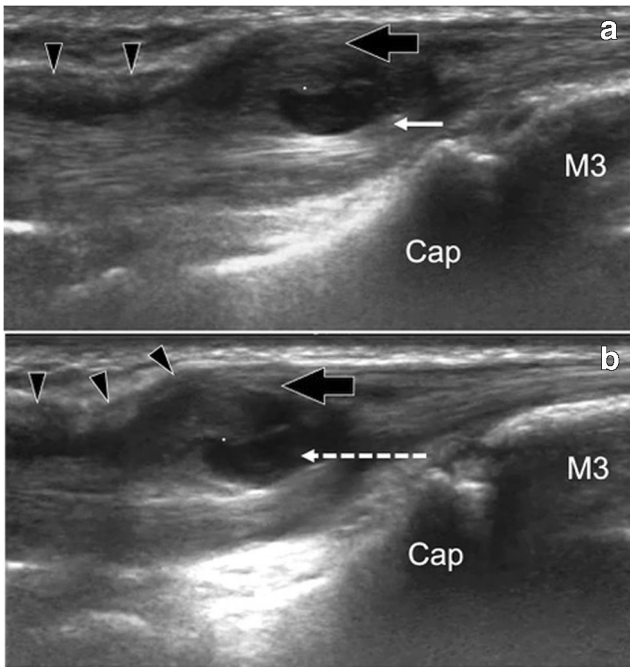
Ultrasound Dynamic examination of EDCST with intratendinous cyst in an 11-year-old gymnast. Sagittal ultrasound image obtained at rest (a) and with active finger extension (b). a Intratendinous ganglion cyst within the index EDC (white arrow) surrounded by hypoechoic thickening of the tendon (black arrow) and focal compression of the ER (black arrowheads). b Proximal displacement of the tendon and ganglion cyst (white dotted arrow) with the confinement of the ganglion cyst under the ER and bulging of the EDC. (M3, third metacarpal bone; Cap, capitatum)
